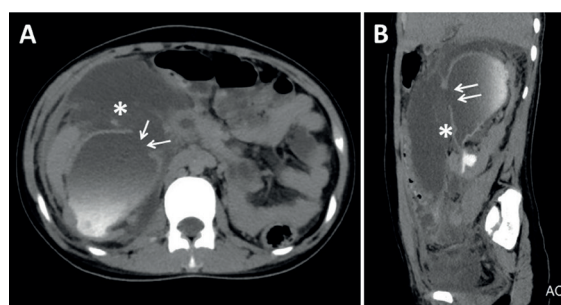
Contrast-enhanced CT, axial (A) and sagittal reformatted (B) images show ruptured dilated renal pelvis (arrows indicate the defect) and retroperitoneal fluid collection (asterisk).
